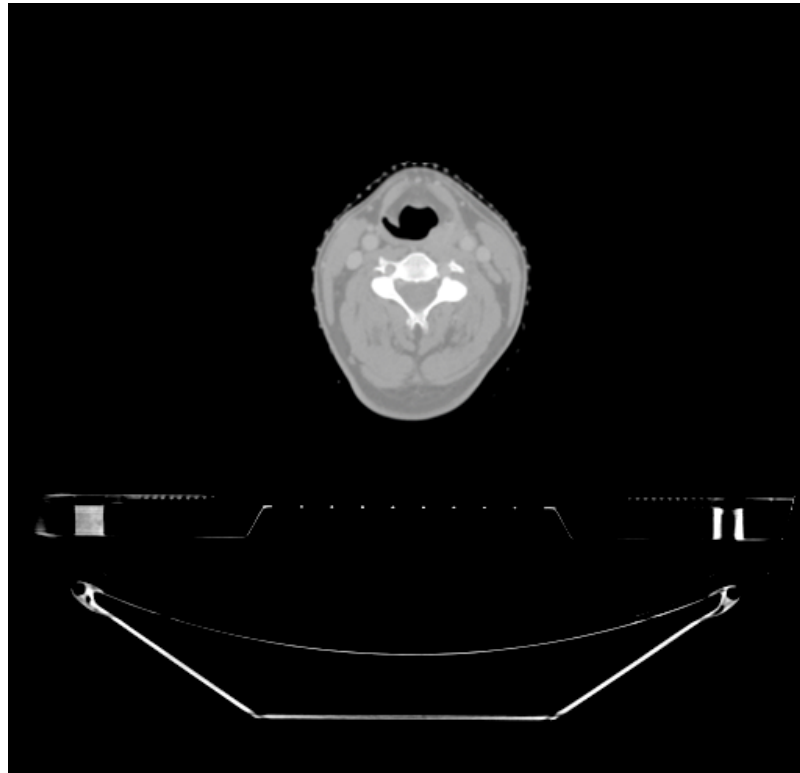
One of the original CT scanning image.
